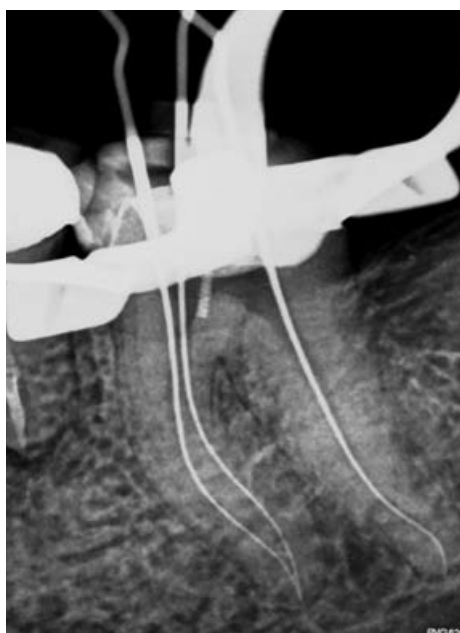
Length determination radiograph. Note the "s"-shaped canal configurations in all three root canals.
